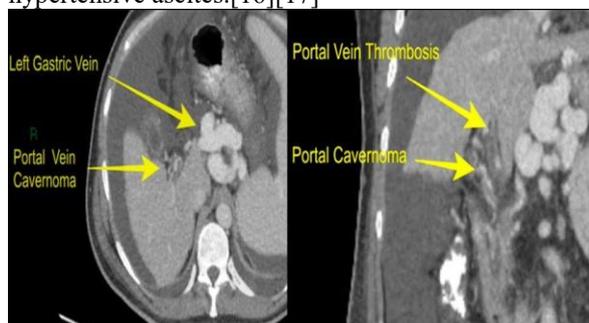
Computed tomography of portal hypertension.
